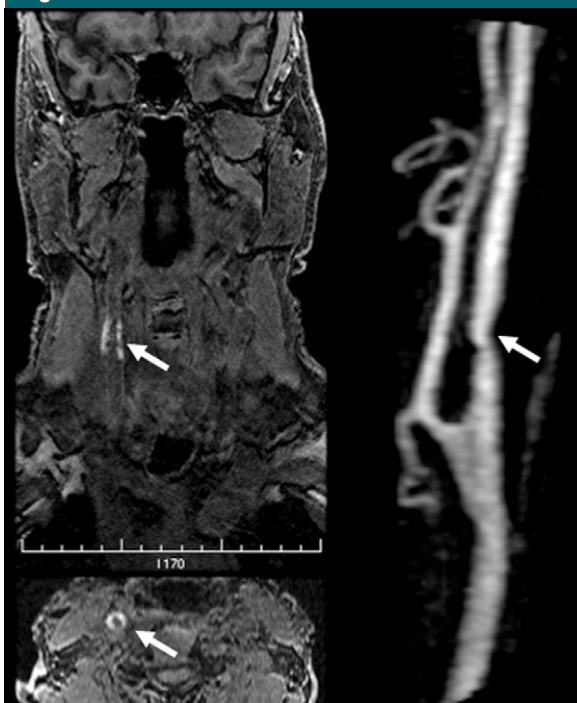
(Top left) Coronal and (bottom left) axial MR images depicting IPH in 71-year-old woman show high signal intensity in the right carotid artery (arrows). Right: MR angiogram of the right carotid artery in same patient shows minimal stenosis (arrow).
